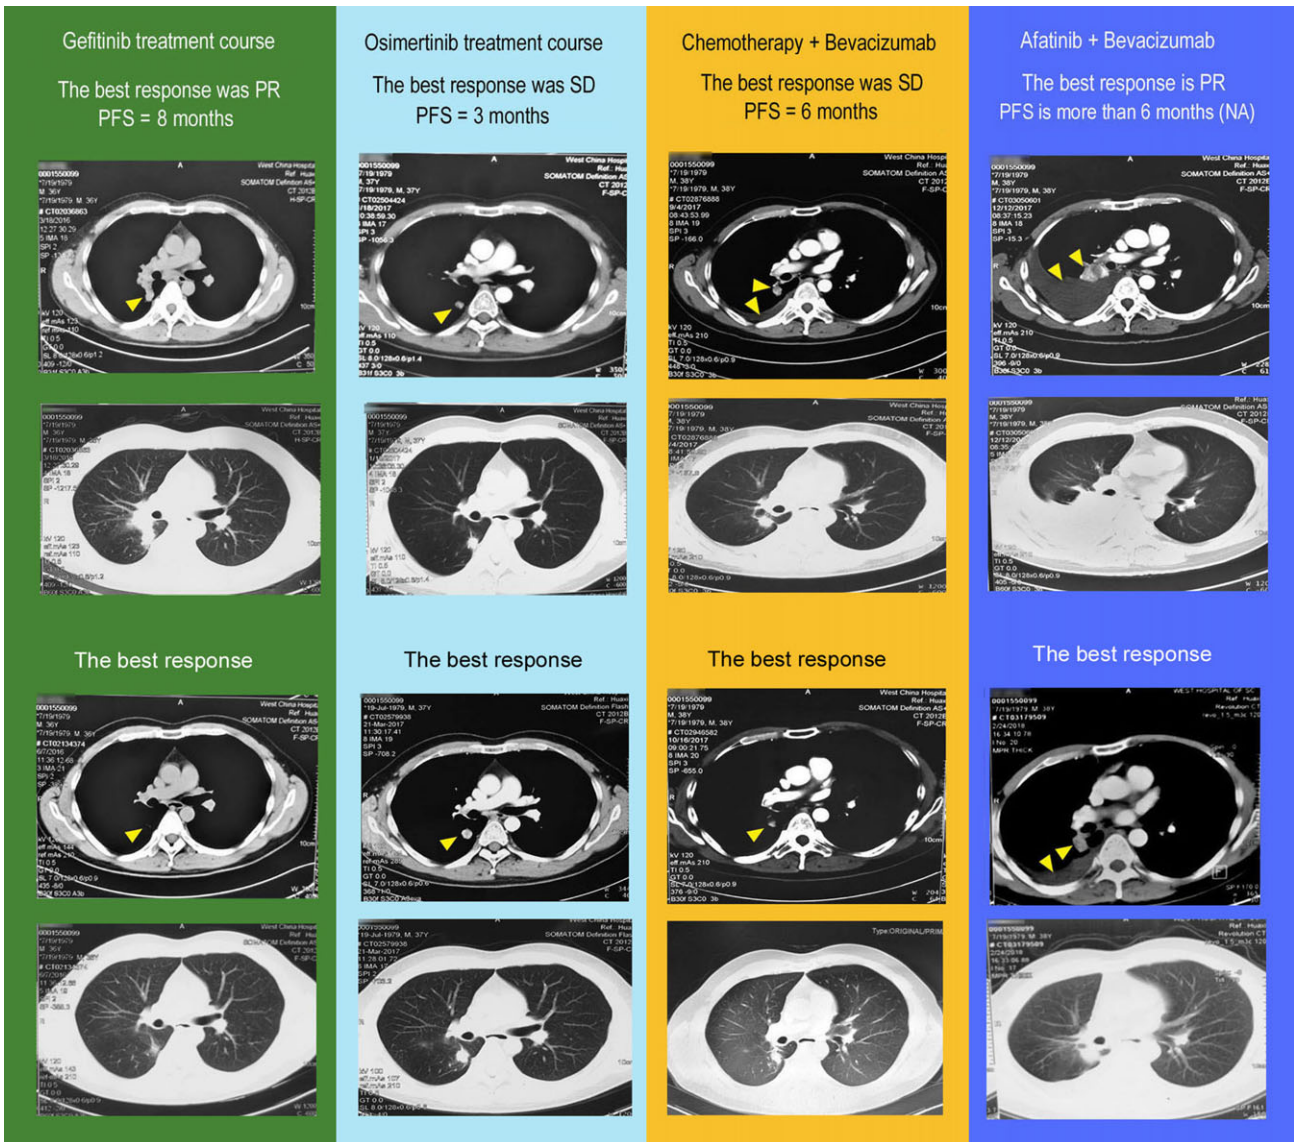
CT scan and response evaluation of the four lines of treatment. Line 1 and Line 3: mediastinal window; Line 2 and Line 4: lung window.
